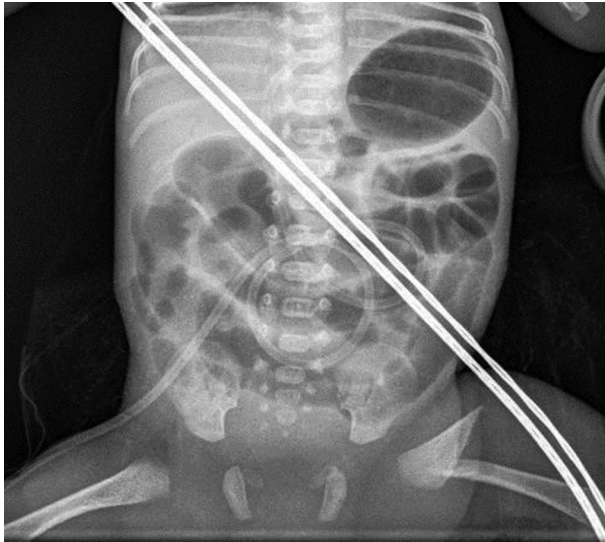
Radiograph Showing a Subtrochanteric Open Fracture in the Newborn
